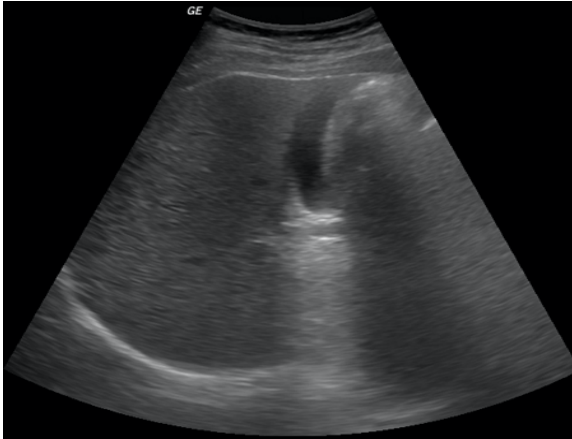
A - Real Ultrasound Machine
